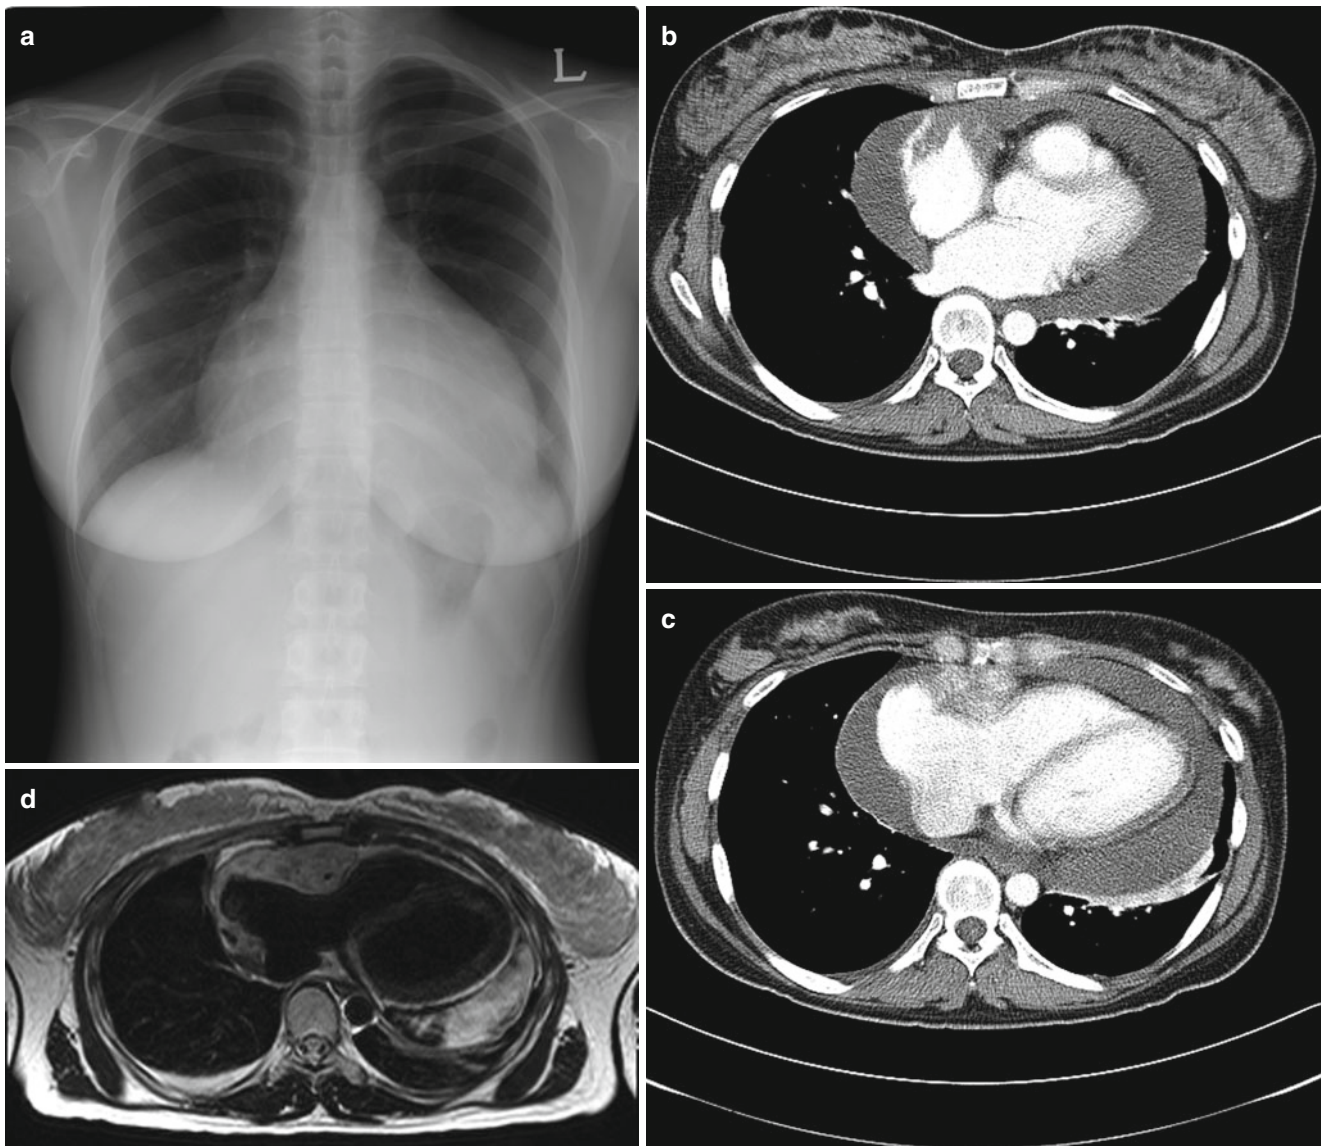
Imaging findings on chest radiography and CMR of angiosarcoma. (a) Chest radiography shows cardiomegaly without pleural effusion or increased pulmonary vascularity. (b, c) CT axial images show lobulated and hyper-enhanced mass around the right atrioventricular groove. The mass invades the RVOT wall. (d) In axial T2-weighted MR image, the mass shows hyper-signal intensity compared with the myocardium and infiltrative growth. The right coronary
